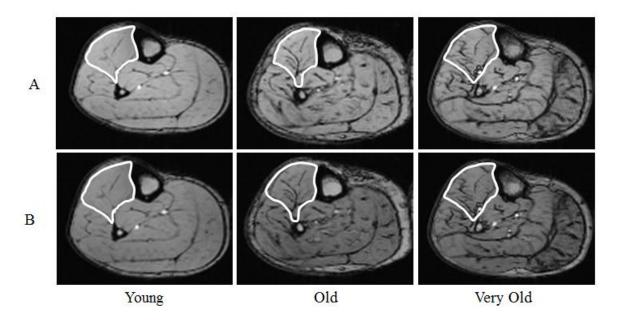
Representative MR images of the right leg of young, old, and very old participants including a sample outline of a ROI in white.
